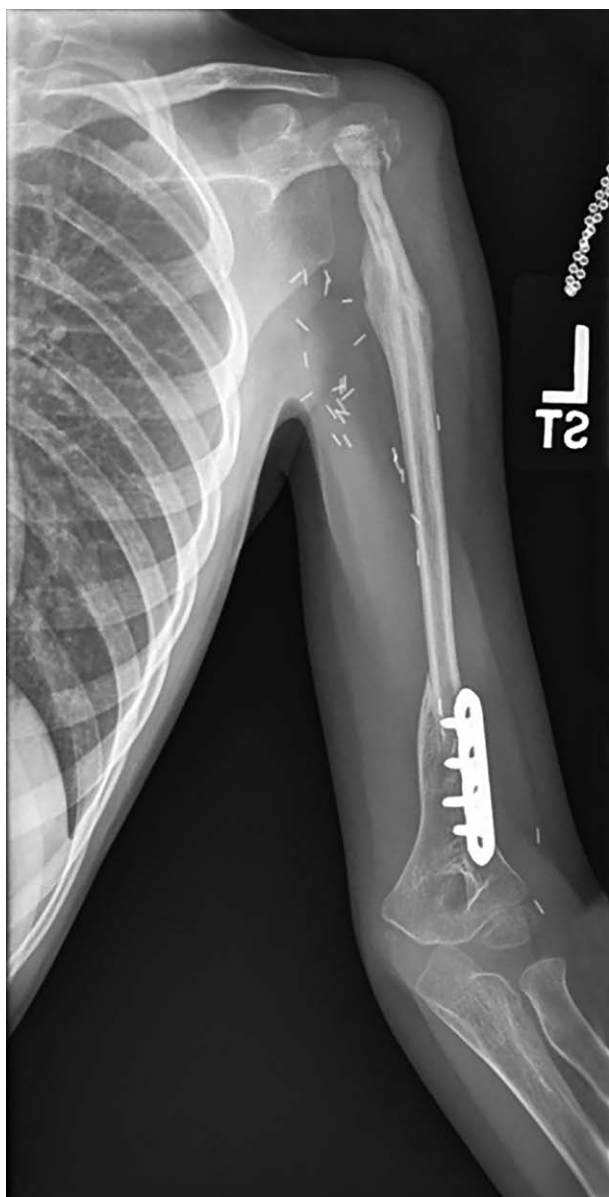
Radiograph at 9 months demonstrating rapid bony healing and callus formation after fracture.
